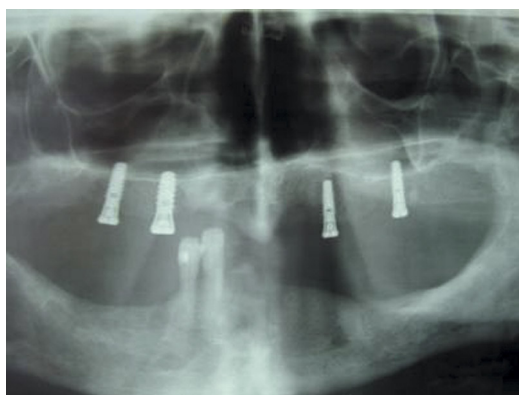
Preprosthetic panoramic radiograph of patient 1.
